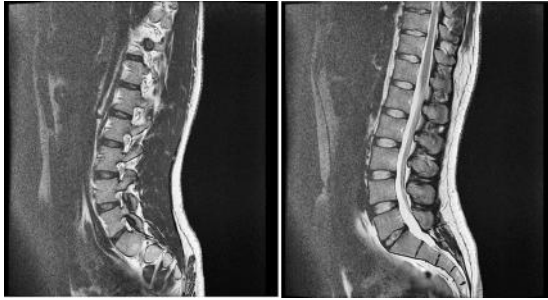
MRI images of the lumbar spine*
